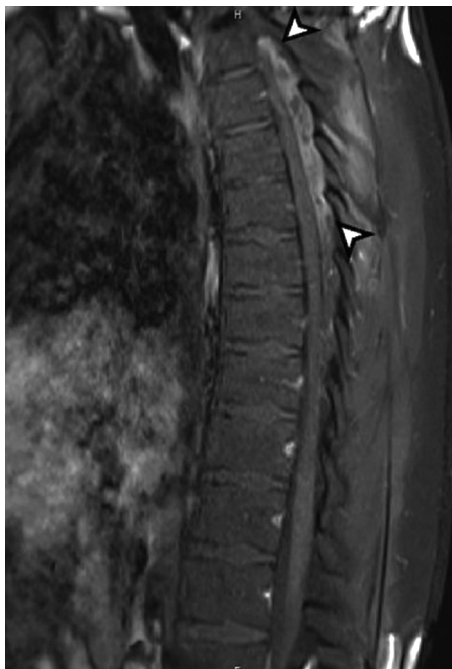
A thoracic spine T1-weighted sagittal MRI with fat saturation, obtained after the intravenous application of a Gd-containing contrast agent, shows intense marginal contrast enhancement of the epidural fluid collection in the vertebral canal (arrowhead). MRI, magnetic resonance imaging.
